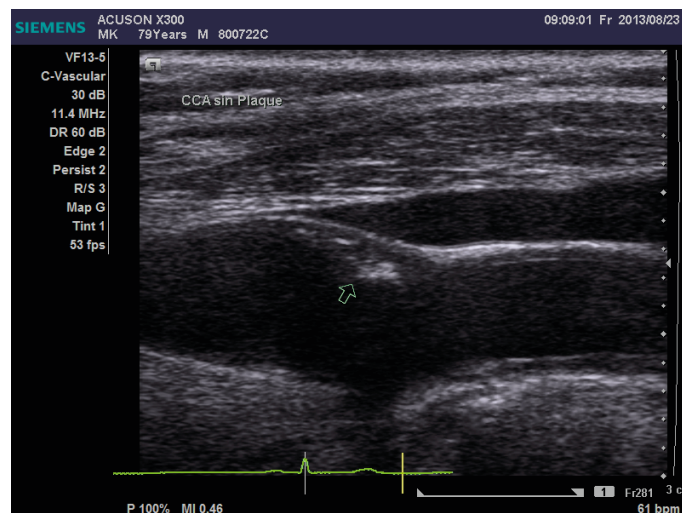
Example of an atherosclerotic plaque detected by ultrasound of the carotid artery. The plaque is situated at the near wall in the bifurcation and indicated by the arrow. The plaque is echogenic and induces a shadowing of the far wall of the bifurcation.
